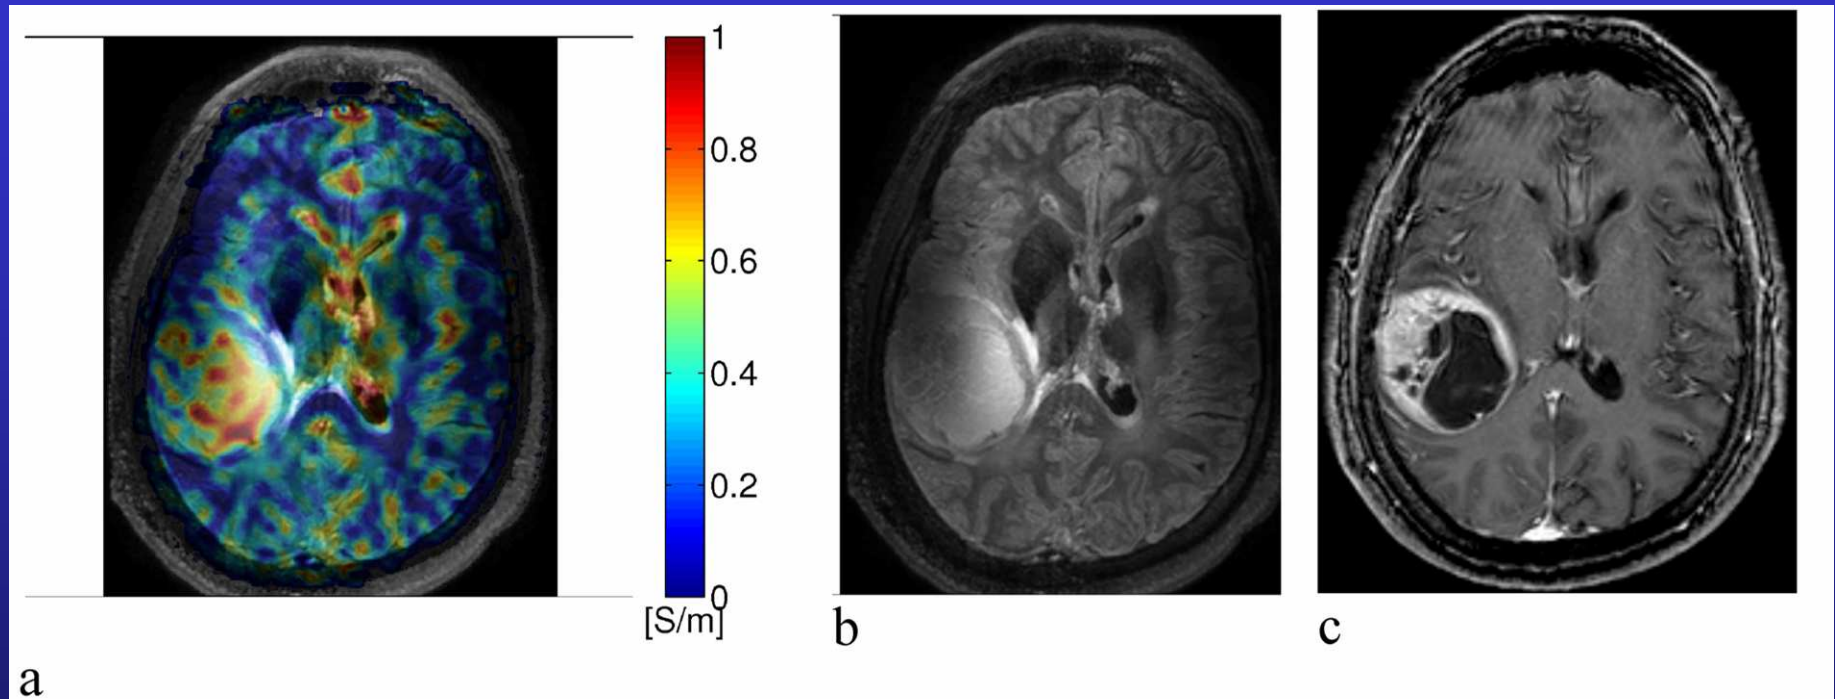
Patient 1: grade IV astrocytoma a) Reconstructed conductivity map overlaid on a FLAIR image. b) FLAIR c) post-contrast 3T T1W
